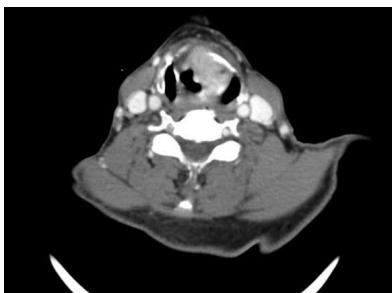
Axial contrast-enhanced CT scan of the neck showing an advanced left laryngeal carcinoma. The image reveals a heterogeneously enhancing soft tissue mass centered in the left hemilarynx, with clear evidence of invasion into the paraglottic space and transgression of the thyroid cartilage. The lesion causes partial obliteration of the airway lumen and extends across the midline, suggesting aggressive local spread
